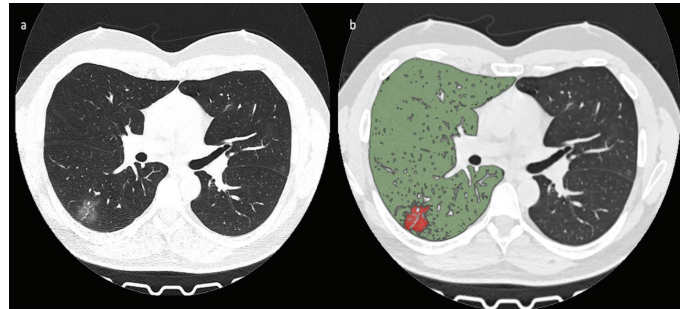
a) Ground glass density area accompanied with vascular enhancement at the lower lobe of the right lung observed on the non-contrast thorax CT of a 34-year-old male patient. b) Total lung volume of lung (green areas, each lung separately) calculated with automatically and pathologic volumes (red areas), calculated using semi-automatic methods
